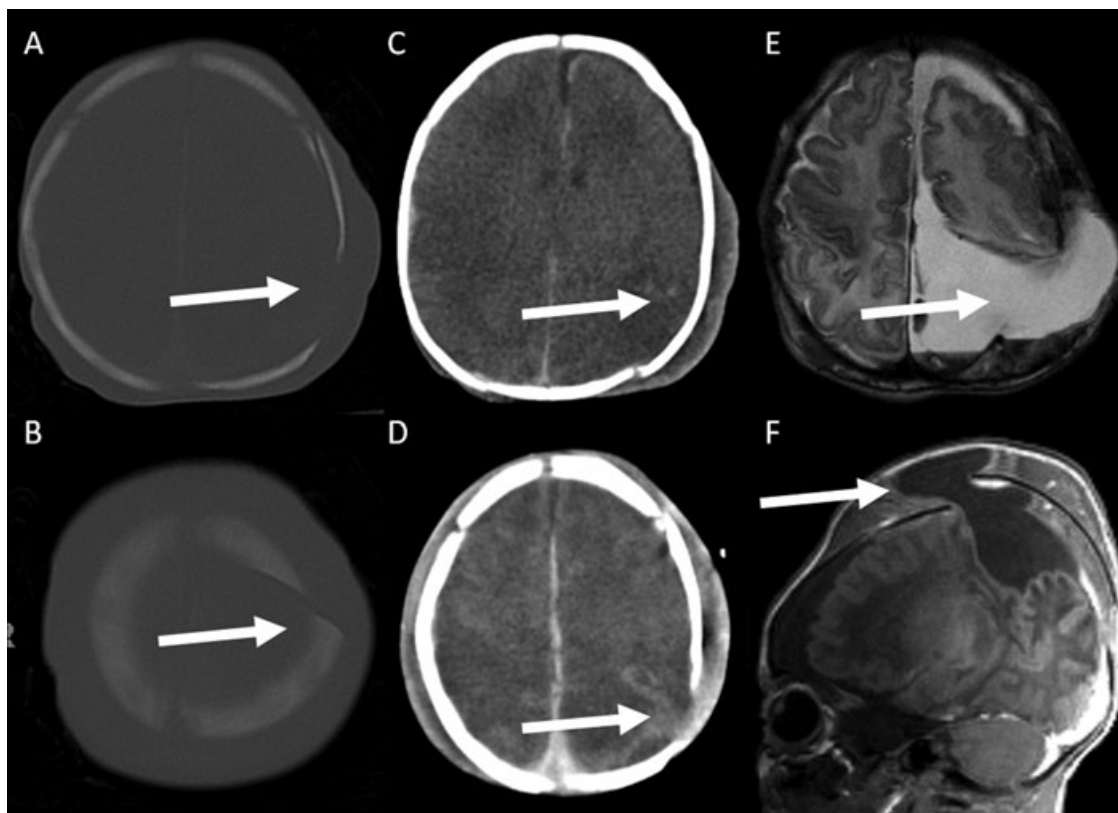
Axial CT images (A–D), axial T2-weighted (E) and sagittal T1-weighted (F) MR images of a 29-day-old boy with a growing fracture resulting from a nonaccidental injury. CT-images (A–D) show a diastatic left parietal fracture (arrow) with mildly hemorrhagic contusion of the adjacent parietal brain (arrow). Follow-up MRI shows interval appearance of a herniation of meninges and underlying brain (arrow) through the widened skull defect (E, F). In addition, a T1-hyperintense supratentorial and infratentorial SDH is noted.
